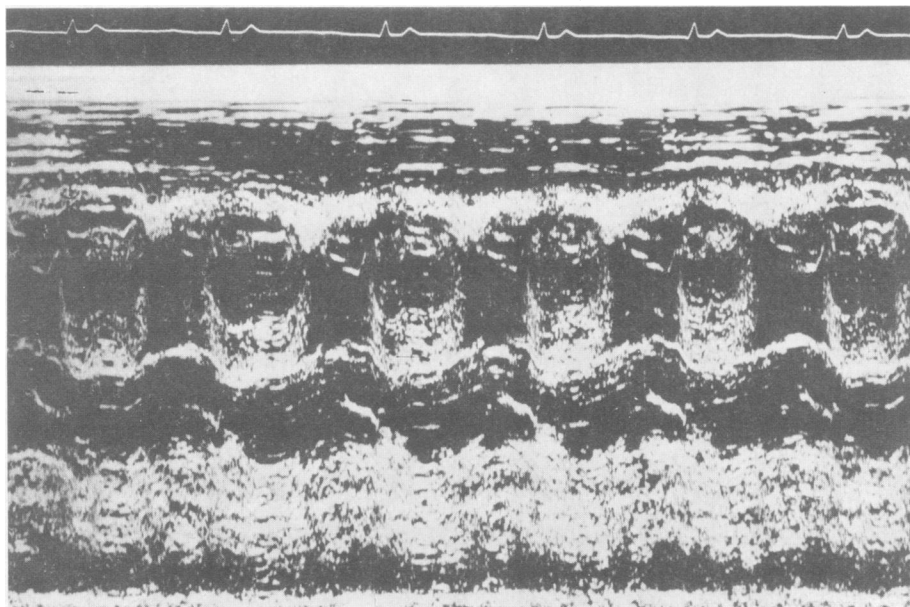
Echocardiogram showing myxoma of right atrium.
